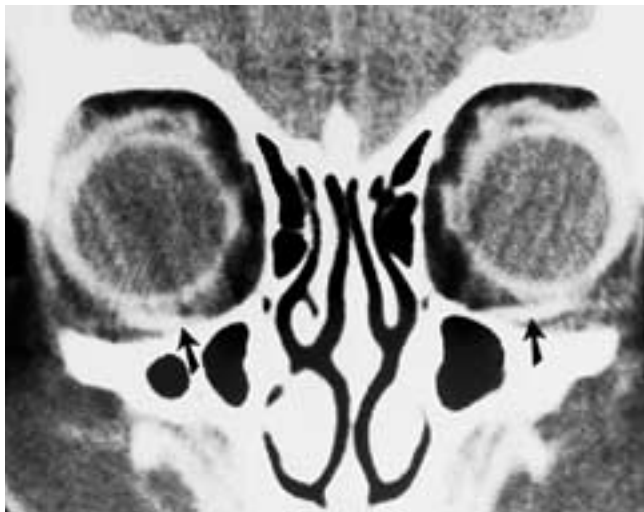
Inferior oblique muscles. Coronal CT scan shows inferior oblique muscles (*arrows*).
